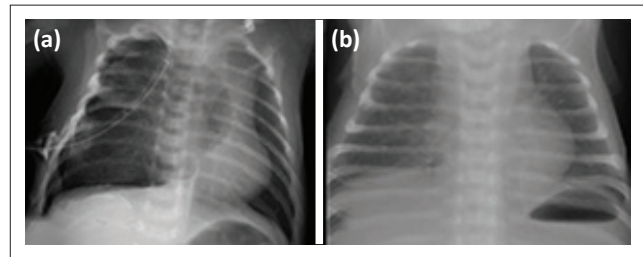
Chest radiograph (a) before and (b) after autologous blood patch pleurodesis
